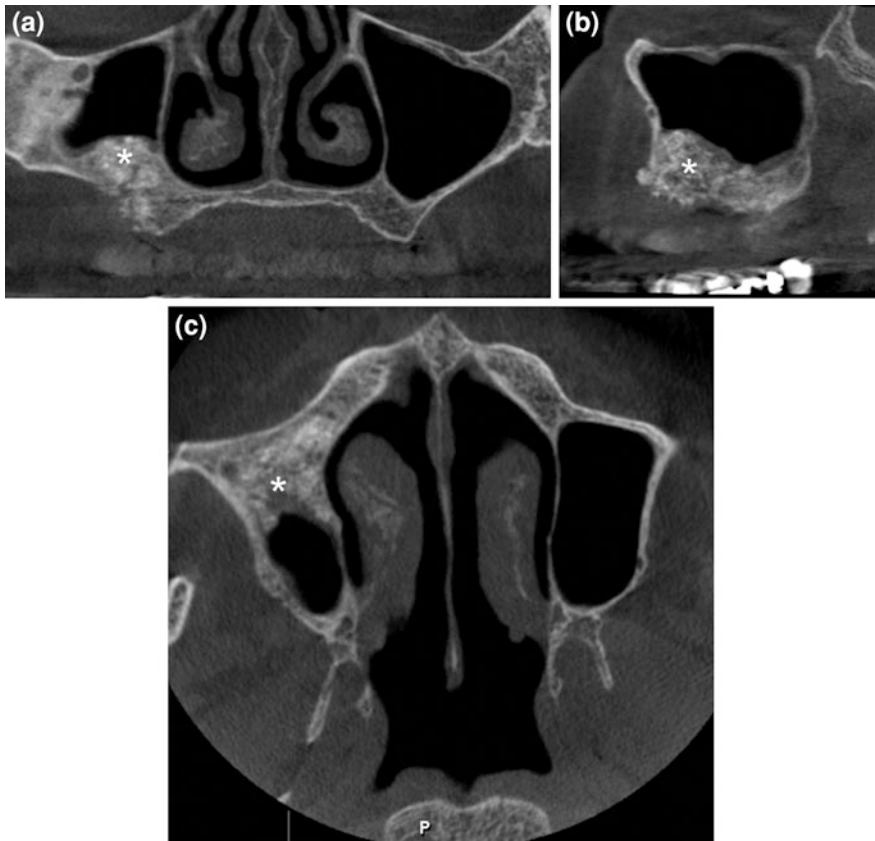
CBCT coronal (a), sagittal (b) and axial (c) scans demonstrating the right sinus lift with bone graft (*) to provide enough bone to place the implant
